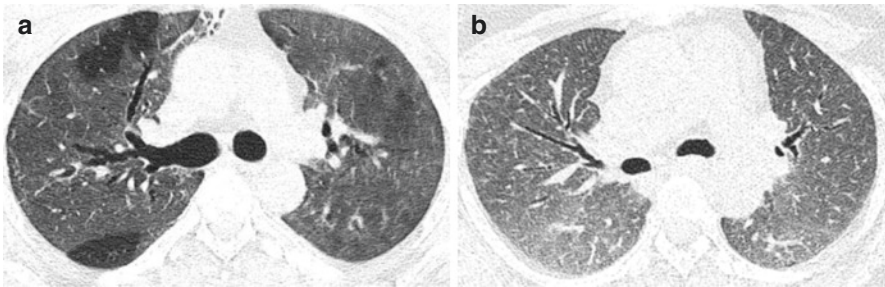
(a, b) HRCT images of two patients of COVID-19 pneumonia demonstrating diffuse GGOs with associated bronchial dilation
